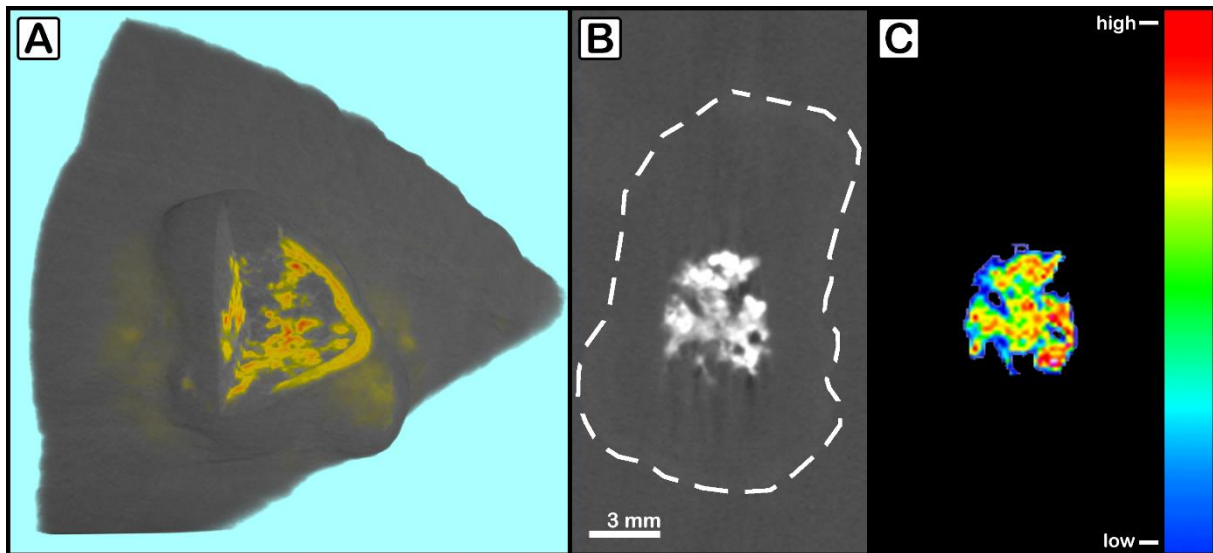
XRF measurement to validate Ba dependent x-ray contrast.
